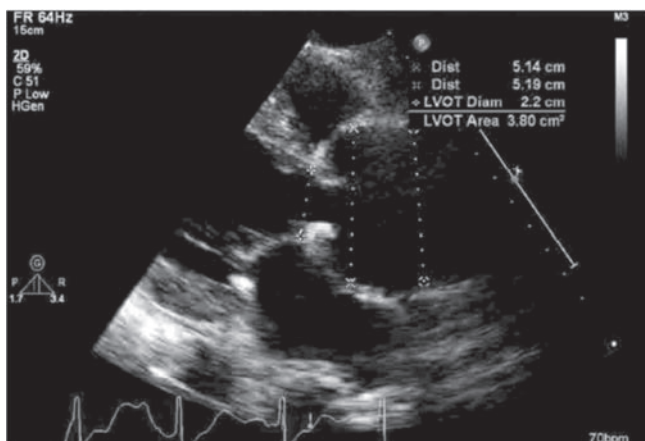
Dilated aortic root from parasternal long axis view.
